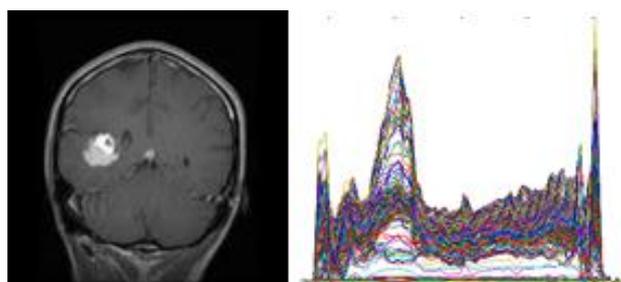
MRI-T1 brain contain tumor (left) and its covariance histogram (right).
